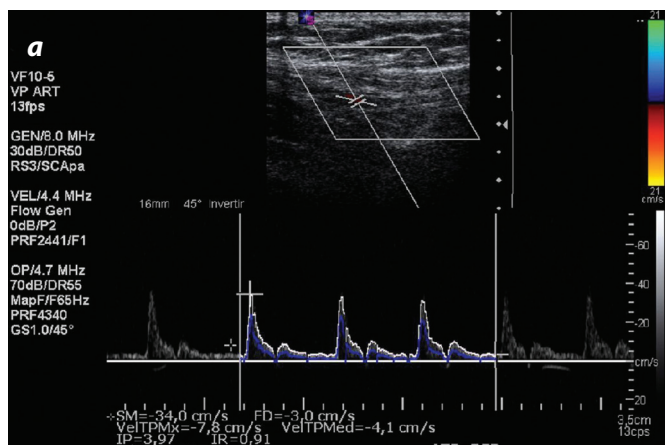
Triplex mode color Doppler ultrasound, showing the thoracodorsal artery in a male patient (a) and in a female (b)
